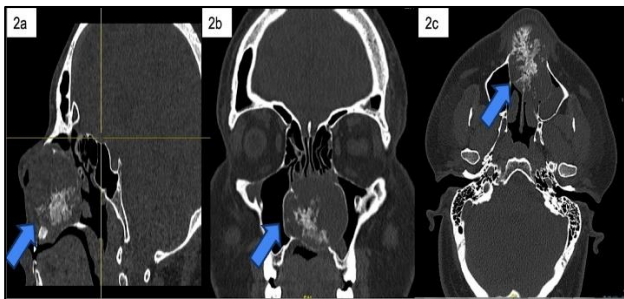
CT BOS and PNS reported aggressive soft tissue mass with ring and arc calcification within anterior bilateral nasal cavity, causing erosion of the ethmoidal air cells, hard palate and anterior nasal septum. (a) Sagittal view (b) coronal view (c) axial view.
